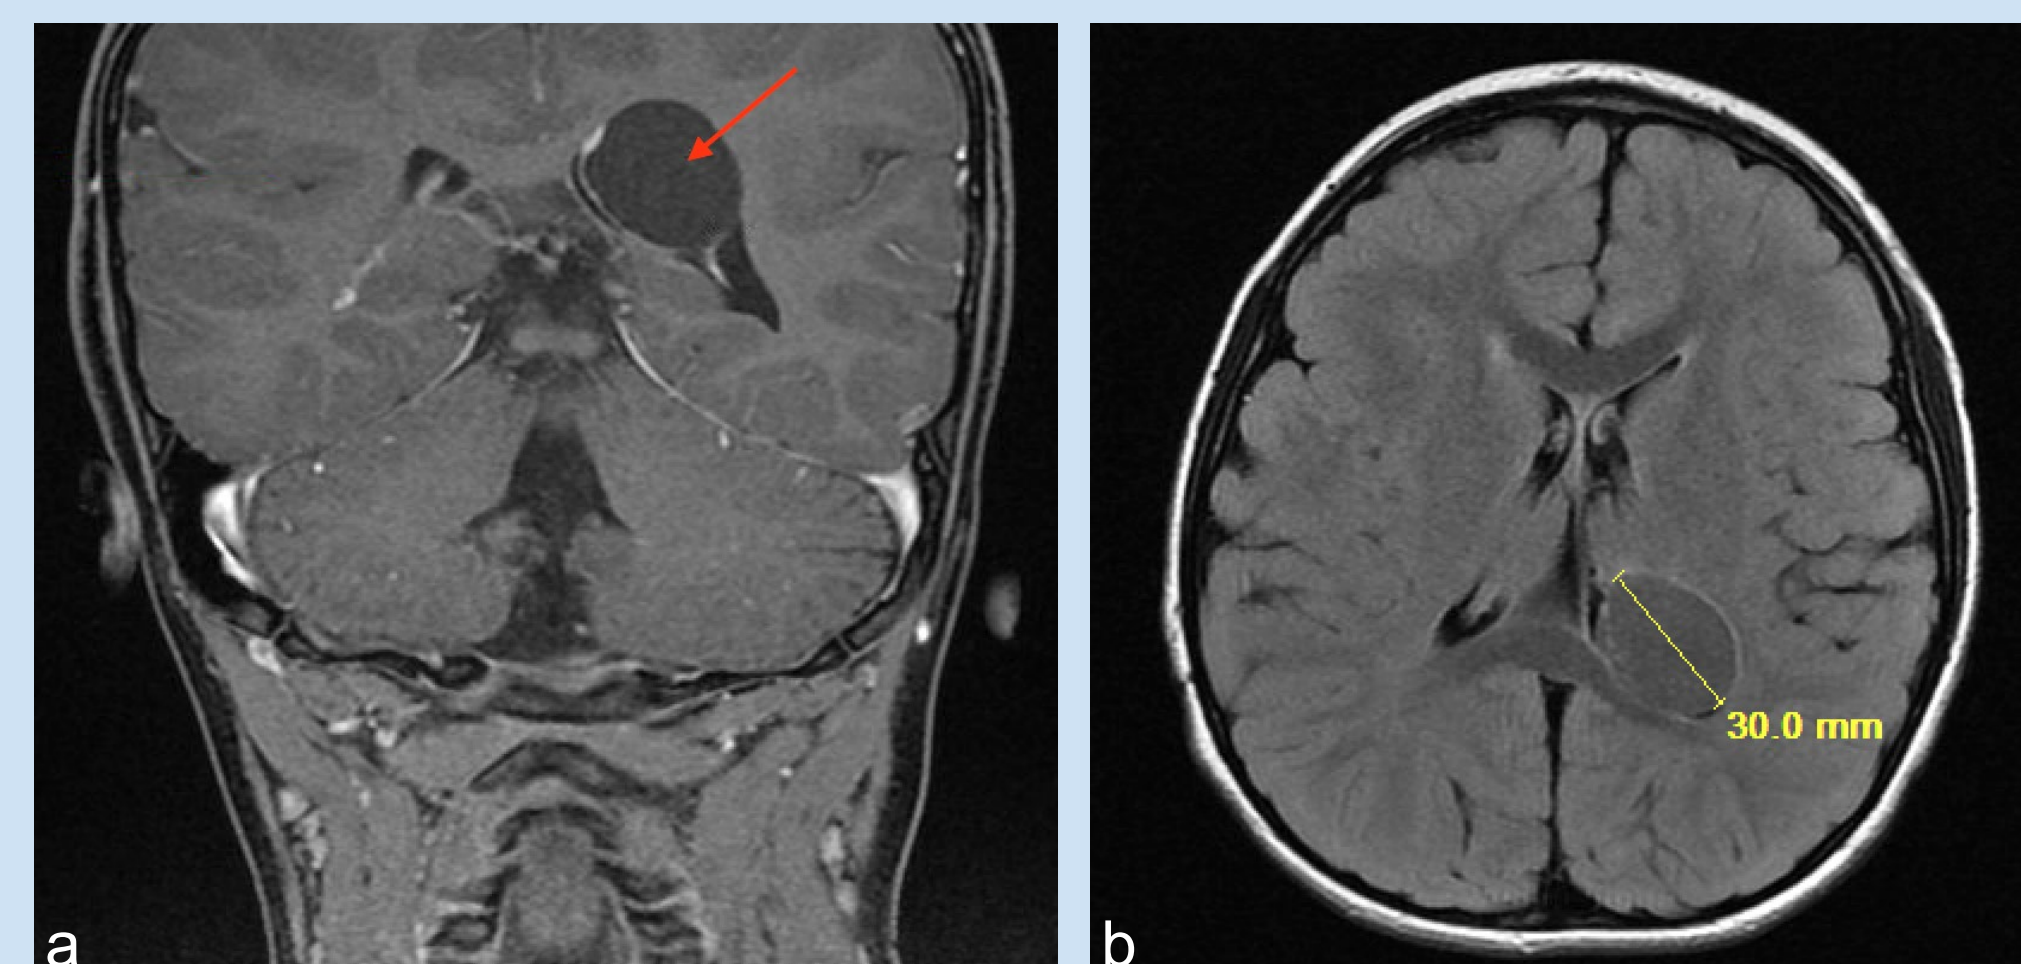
Case 4, left ventricle choroid plexus cyst (MRI), coronal (a) and axial (b) cuts.
